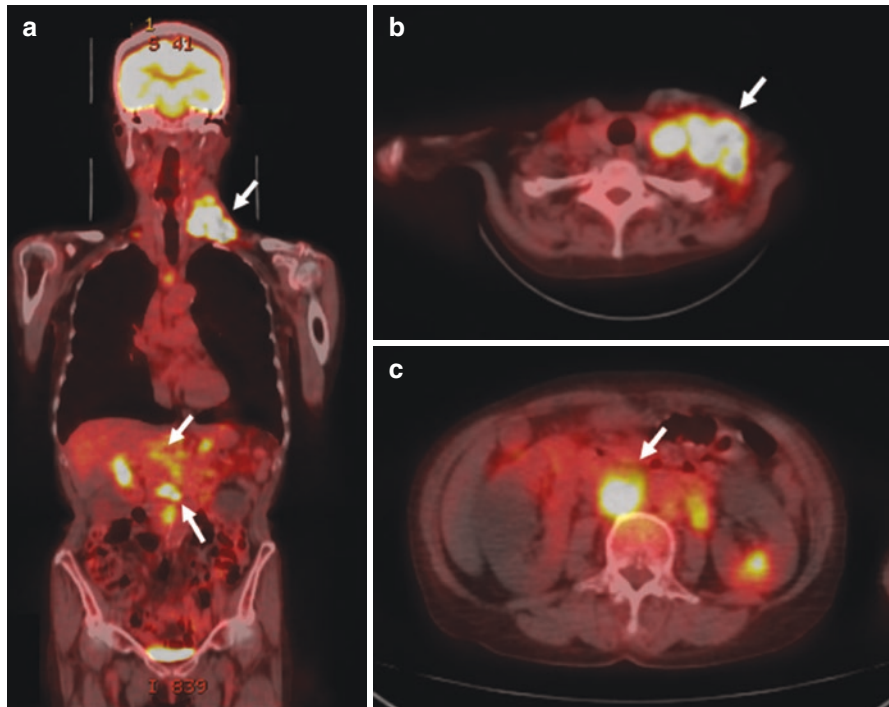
Initial staging with ¹⁸F-fluorodeoxyglucose (FDG) PET/CT in Hodgkin Lymphoma. (a) Coronal image shows accumulation of FDG in left cervical, mesenteric and para-aortic lymph nodes (arrows). Axial images of left cervical lymph node (b) and para-aortic lymph node (c) with SUVmax 12.5 and 10.5, respectively
